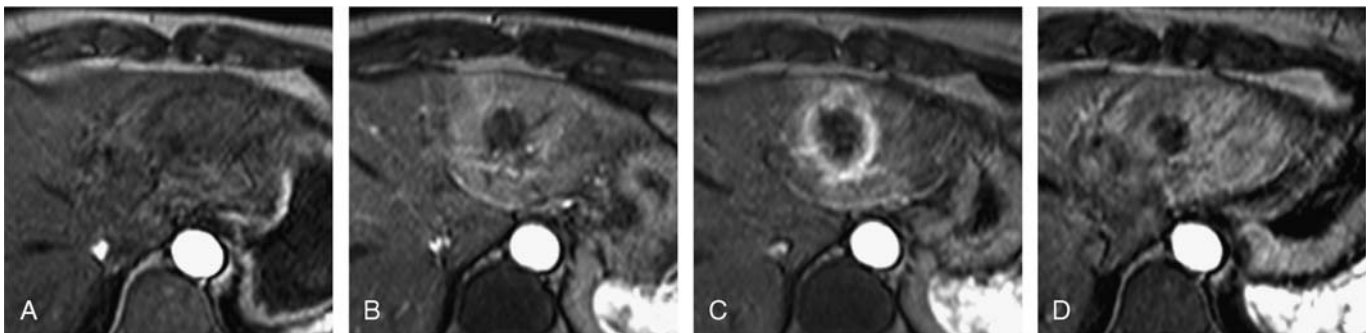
MRI patterns after IRE—arterial contrast enhancement. Same patients as shown in Figure 1. Appearance of the IRE ablation zone on axial contrast-enhanced T1-weighted gradient echo sequences in arterial phase at different time points: pre-IRE (A), 2 hours after IRE (B), 24 hours after IRE (C), and 1 week after IRE (D). Within 2 hours after IRE, we observe a homogenous arterial enhancement of the entirety of the ablation zone (B). This changed at 24 hours to a rim enhancement (C), which persisted in this case until 1 week after IRE.
